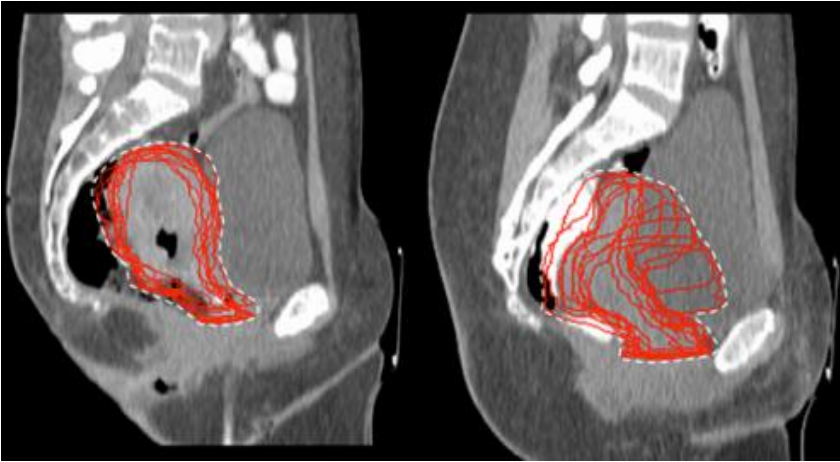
Sagittal cuts of the CT-scans showing inter-patient variability in cervix-uterus motion for two cervical cancer patients during the entire treatment course. Image is taken from (32)
